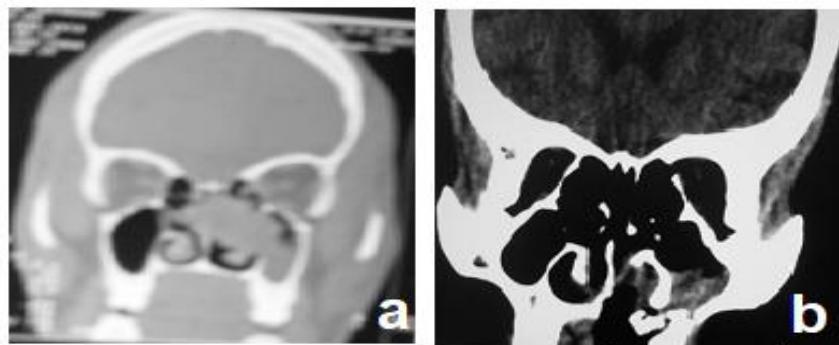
a. Bone windows of coronal view of CT scan of sinuses showing carcinoma of the left maxillary antrum arising from the medial wall. b. Conal sinus view in CT scan showing soft tissue debris/mass in the left maxillary sinus.
